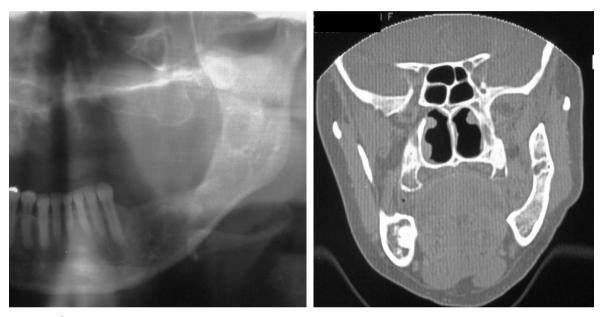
A: Panoramic X-ray showing a radiolucent mandibular ramus. B: Bone CT scan showing a small lesion at the mandibular ramus, suggesting a recurrence of the neoplasia.
